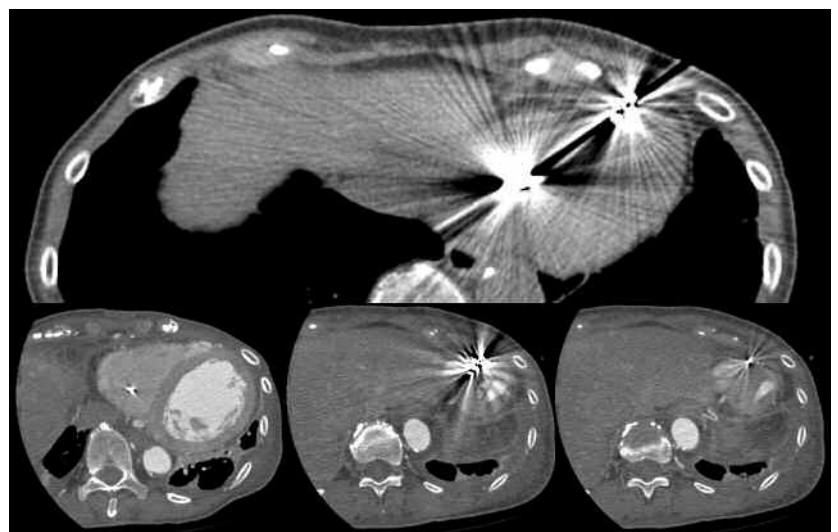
Computed tomography scan of the chest demonstrating perforation of the right ventricular lead through the right ventricular myocardium into the pericardial space.
